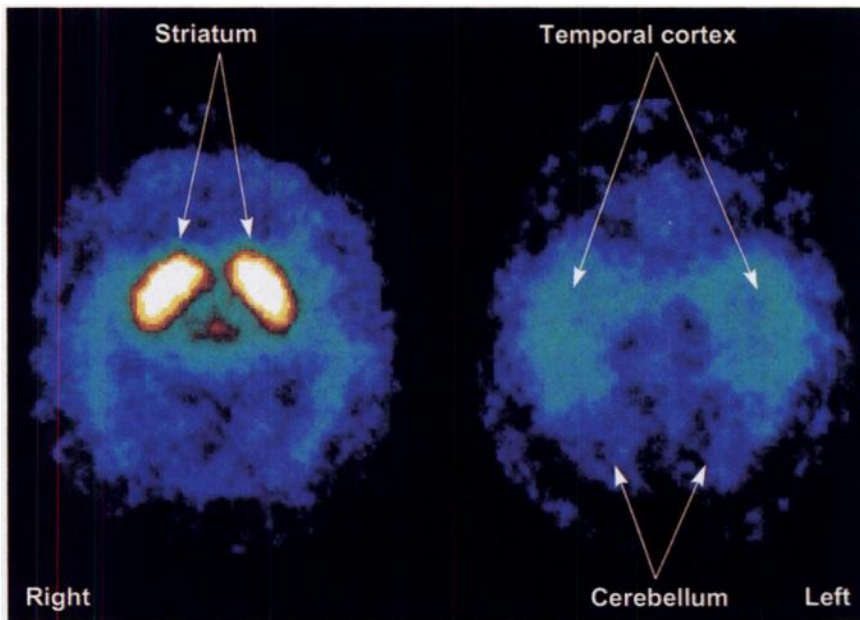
Selected transverse [¹²³I]epidepride SPECT images (summed over 51–81 min after injection in participant 1) at level of striatum (left) and inferior temporal cortex (right). High uptake is seen in striatum, whereas inferior temporal cortex shows slight but discernibly greater uptake than that in cerebellum. [¹²³I]Epidepride D_2 binding in this participant was 24 times lower in temporal cortex than in striatum.
